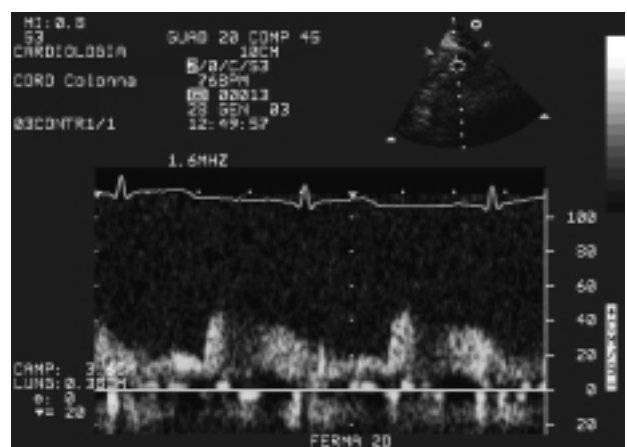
Pulsed wave Doppler envelope recorded in the distal portion of the left anterior descending coronary artery. The flow velocity shows a biphasic pattern with a smaller systolic component and a larger diastolic one, typical of the normal coronary flow in large epicardial coronary arteries.
